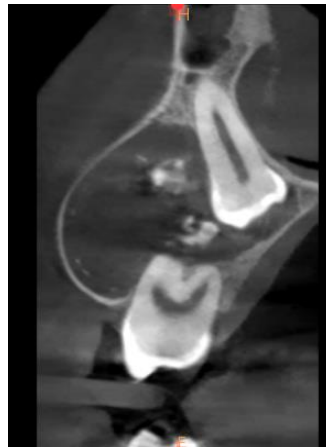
Axial CBCT reveals involvement of Buccal and Palatal cortical plates*
